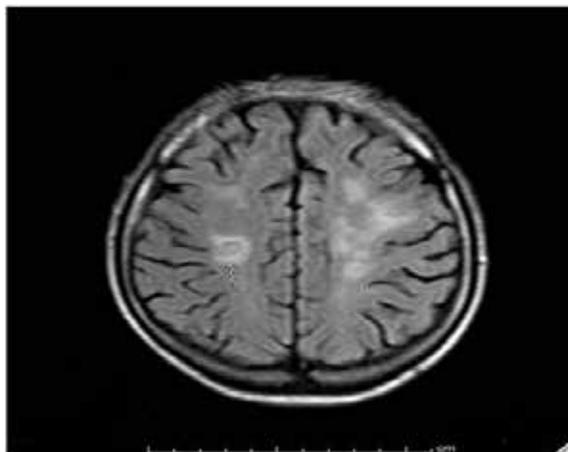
Cranial MRI image of the patient
